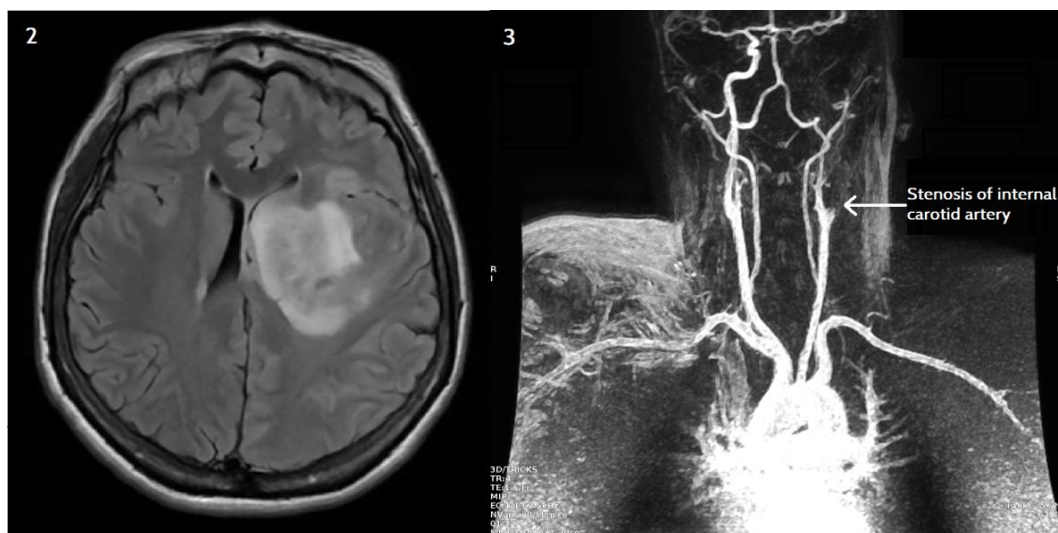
Brain magnetic resonance in T2 FLAIR sequence showing a change of intensity (hypointense) of the left cerebral hemisphere with perilesional edema compressing the cerebral ventricles. Figure 3. Angioresonance showing area of stenosis 1 cm from the left carotid bifurcation.
